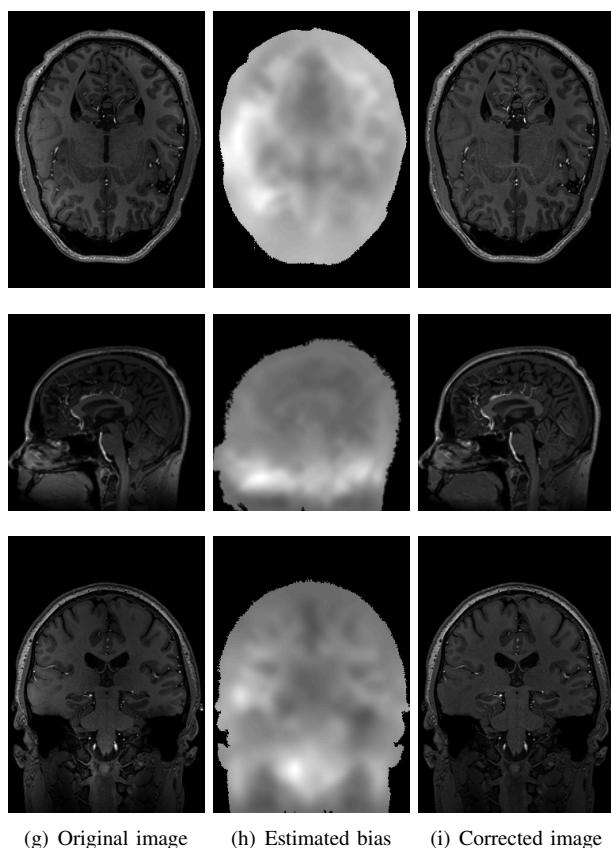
Axial, sagittal and coronal view of Human 7T T1 MRI. (a) Original image; (b) Estimated bias field and (c) Corrected image.
